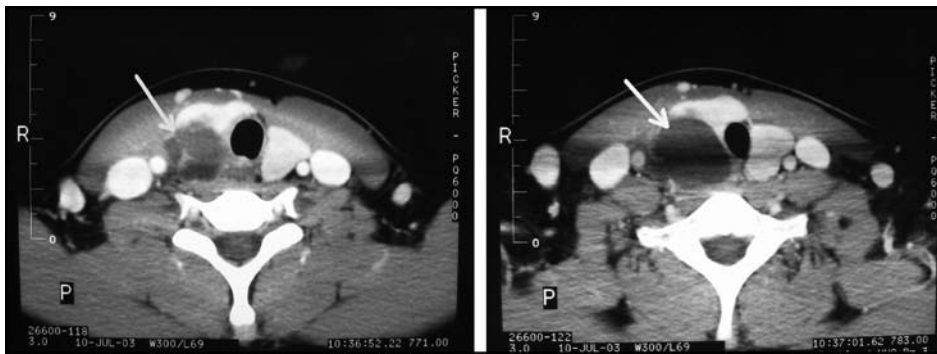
Contrast CT scan showing the nonenhancing right neck mass (arrow), posterior to the right thyroid lobe. The mass was deviating the trachea.
